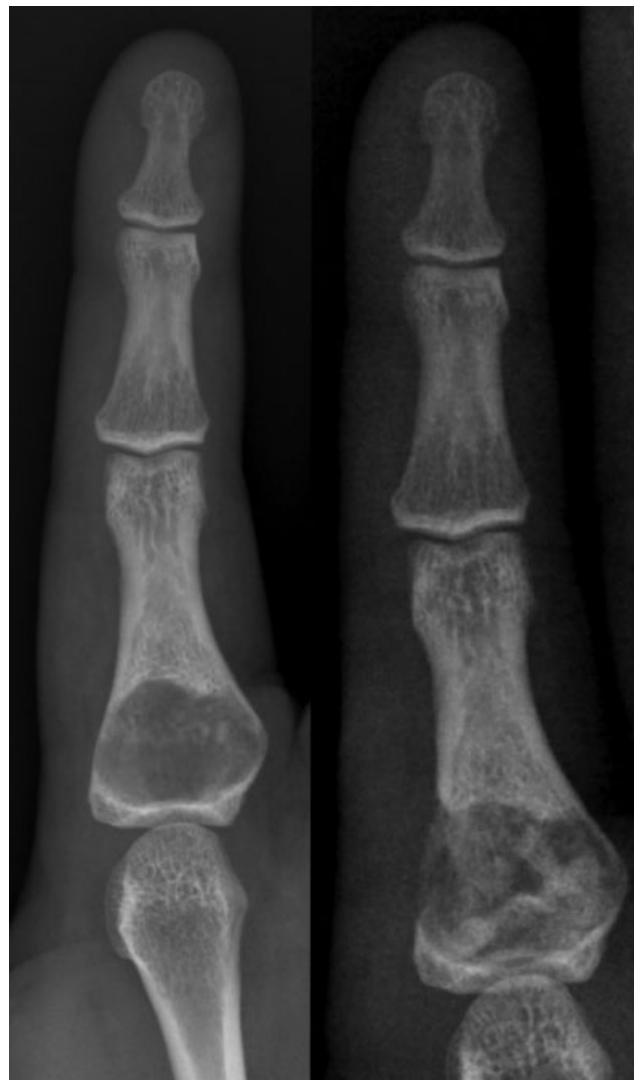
Pre- and postoperative roentgenograms of the index finger. The picture on the left shows a tumor (enchondroma) in the proximal phalanx of the index finger, and the picture on the right shows the appearance after tumor resection and cavity filling with cylinders of cancellous bone graft.
